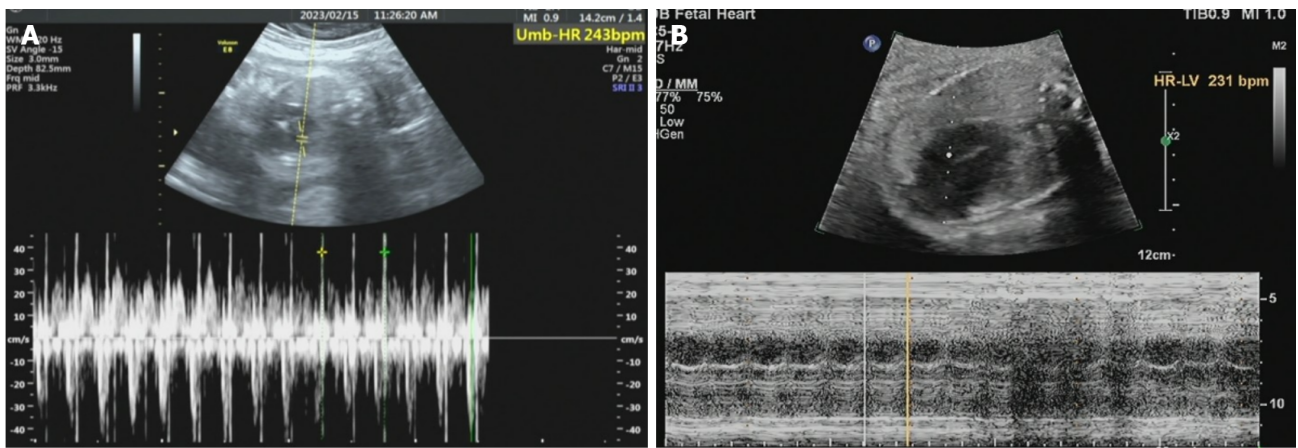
February 15, 2023, 31 + 2 B-mode ultrasonography images obstetric color ultrasound and fetal heart color ultrasound. A: B-mode ultrasonography images obstetric color ultrasound; B: Fetal heart color ultrasound.
